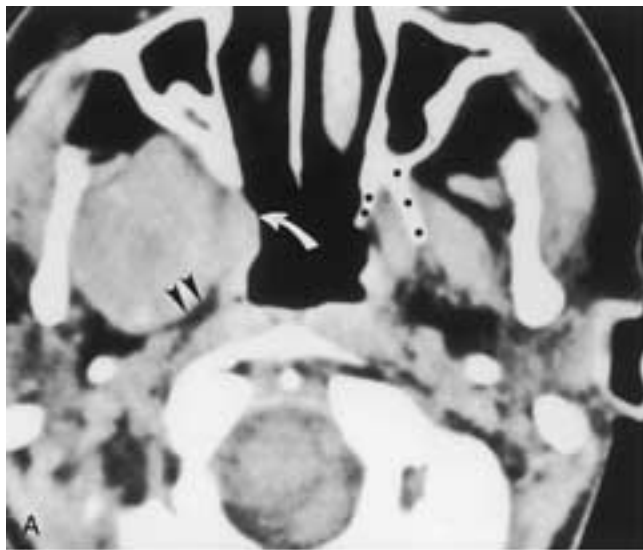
Aggressive fibromatosis (extraabdominal desmoid). A, Axial contrast-enhanced CT scan demonstrates a nonenhancing mass involving the right masticator space centered within the pterygoid musculature. The lesion encroaches upon the right parapharyngeal space fat (*arrowheads*). It also slightly encroaches upon the nasopharyngeal air shadow on the right (*white curved arrow*), producing an abnormal contour compared with the left. The pterygoid plates, well visualized on the left (*black dots*), have been eroded by this lesion and are absent on the right. Coronal T1-weighted MR noncontrast image (B) demonstrates that the lesion is slightly hyperintense to muscle. Mild enhancement was noted following contrast administration as seen on this axial T2-weighted image (C). This desmoid tumor became progressively more hyperintense on the proton density and heavily T2-weighted MR images.
